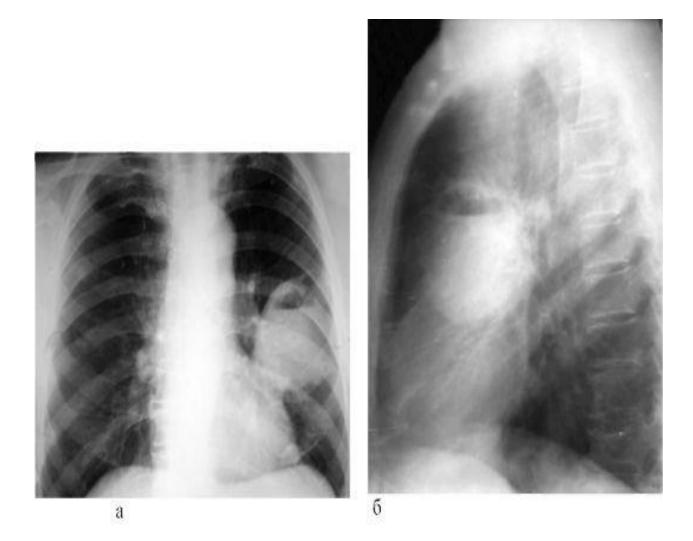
Figure to task 8. X-ray of patient D., 28 years old.
